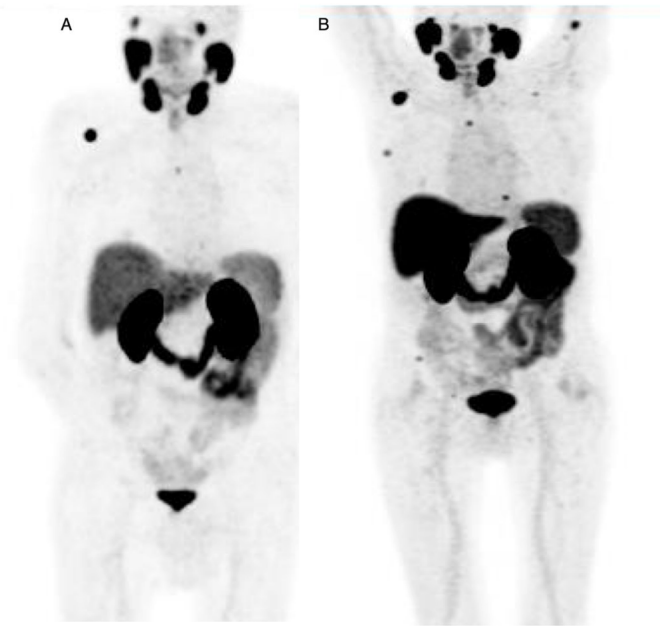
PPP for appearance of more than 2 new distant lesions. 77 years old patient, s/p radical prostatectomy (pT3bpN0 Mx, Gleason Score 4+4, iPSA=11 ng/mL). Consecutive treatment with ADT. At presentation of BCR baseline PSMA PET (A) showing some PSMA avid lesions. After additional treatment (B) the scan reveals several new lesions (arrows). According to PPP more than two new PSMA avid lesions and accordingly progression.
